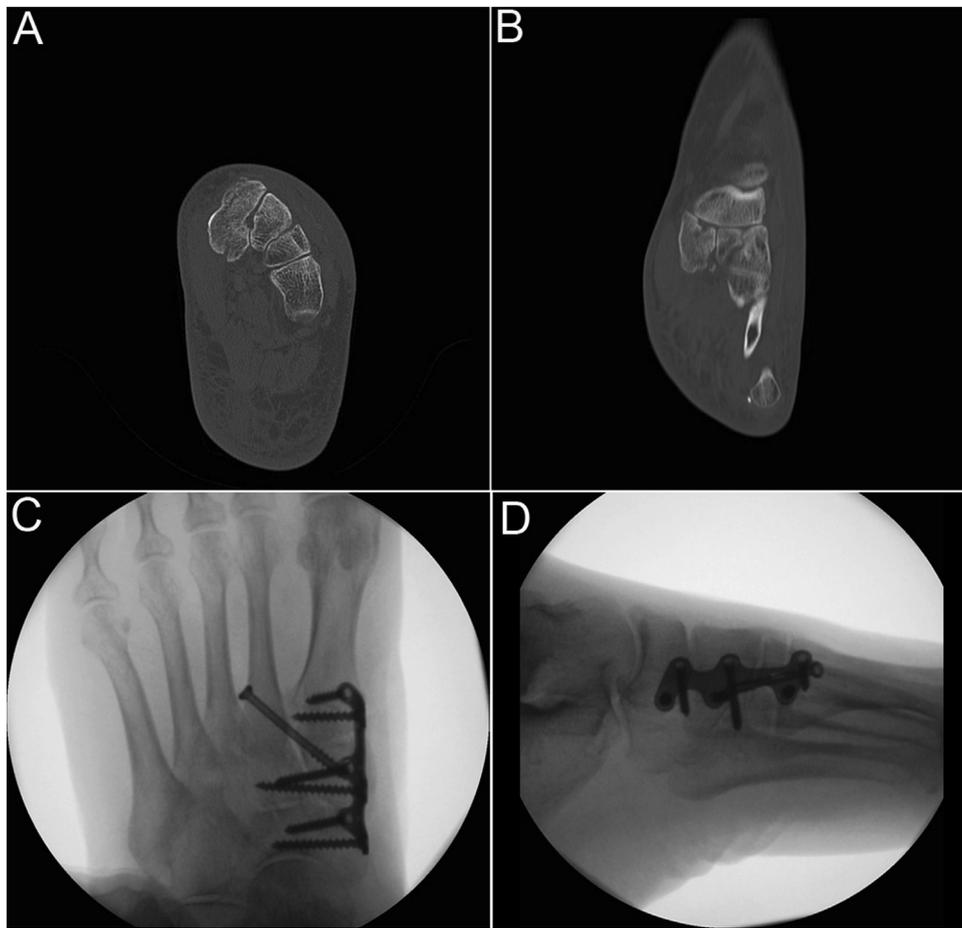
Pre-operative coronal and axial CT images demonstrating a fracture-dislocation of the medial naviculo-cuneiform joint (Type C). Intra-operative fluoroscopic images demonstrate reduction and hold of the avulsed Lisfranc ligament and bridge plating of the dislocation of the NCJ.
